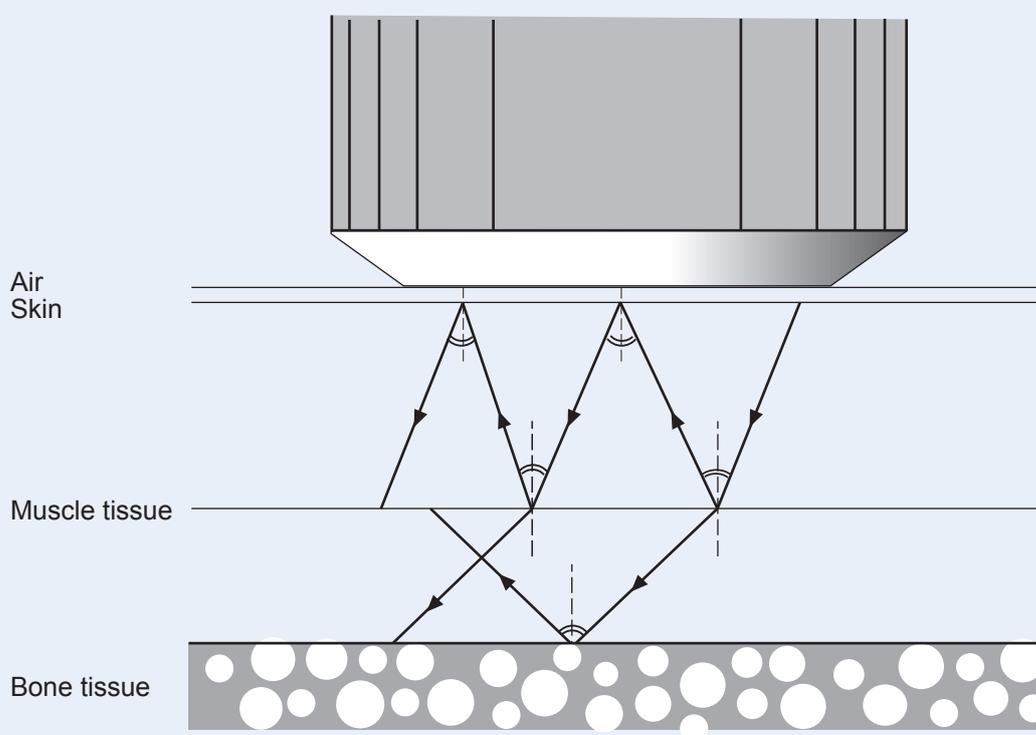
Dispersion of the ultrasound bundle through reflection
